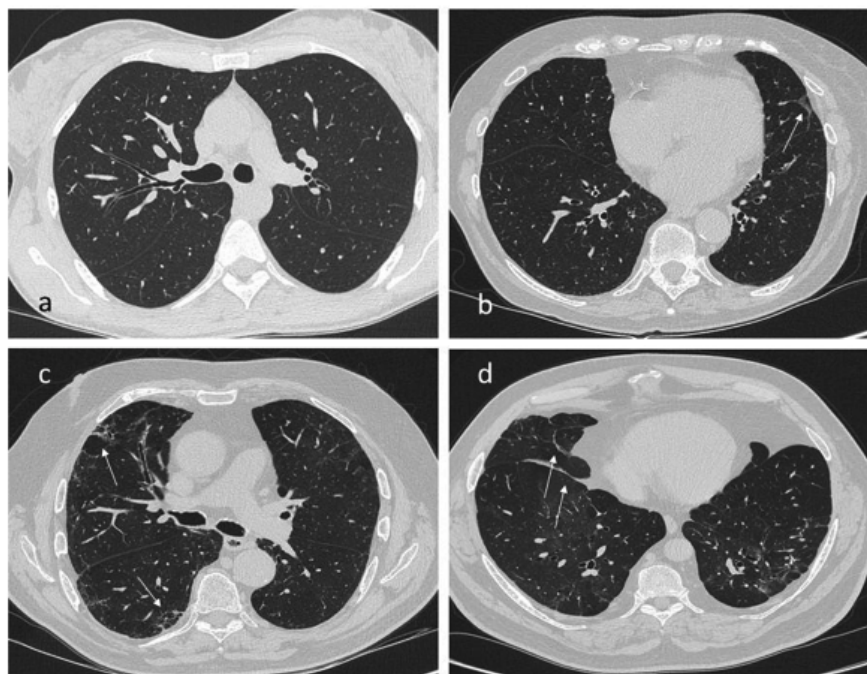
Subdivision according to parenchymal bands severity degree at 18 months CT. a) No visible alterations. b) Mild parenchymal bands. c) Moderate degree. d) Severe parenchymal bands.
